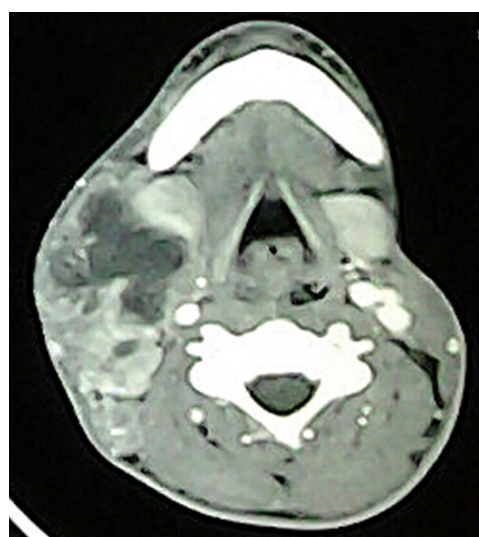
The axial computed tomography of the neck showed an irregular multiseptated peripherally enhancing lesion with central hypodensity, consistent with abscess formation in right anterior and right submandibular region.
